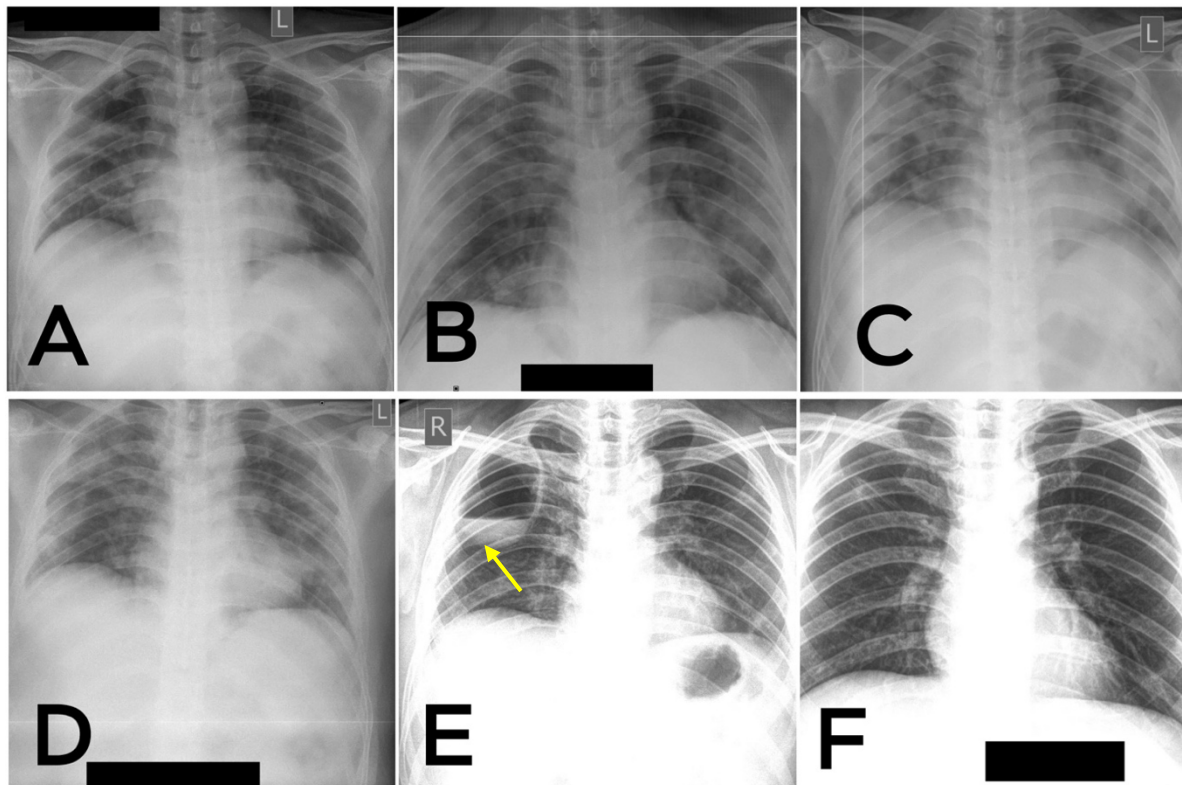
Chest X-rays of the patient were obtained on the first day of hospitalization and demonstrated ground-glass opacities in both lung fields, indicating typical COVID-19 pneumonia (A). On day 7 of hospitalization, radiological examination showed ground-glass opacities in both lateral lung fields, indicating typical COVID-19 pneumonia; compared with the previous X-ray, the condition had worsened (B). On day 10, chest X-ray revealed extended COVID-19 typical pneumonia (C). Chest X-ray of the patient on day 15 of hospitalization demonstrated normalized imaging and less infiltration (D). Two weeks after being discharged, an air-fluid level was seen in the upper lobe of the right lung (yellow arrow), and imaging indicated a lung abscess (E). Four weeks after the lung abscess was revealed and empirical antibiotic treatment was given, the chest X-ray finally normalized and no longer demonstrated a lung abscess (F).
